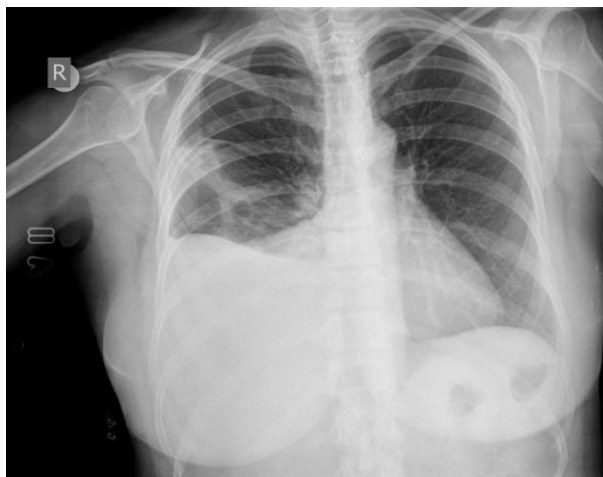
Chest radiograph demonstrating right-sided pleural effusion in patient
